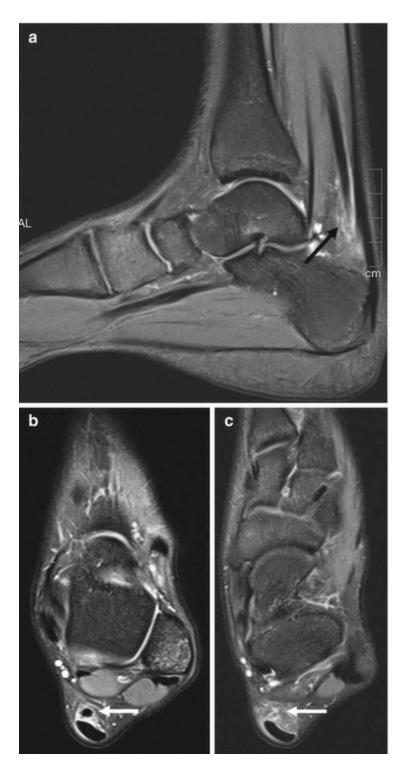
(a) Sagittal fat-suppressed T2-weighted MRI demonstrates complete tear of the plantaris tendon distally with some retraction (*arrow*). (b, c) Sequential axial fat-suppressed T2-weighted MRI again demonstrate complete tear of the plantaris tendon distally with thickened retracted tendon (*white arrow*)
